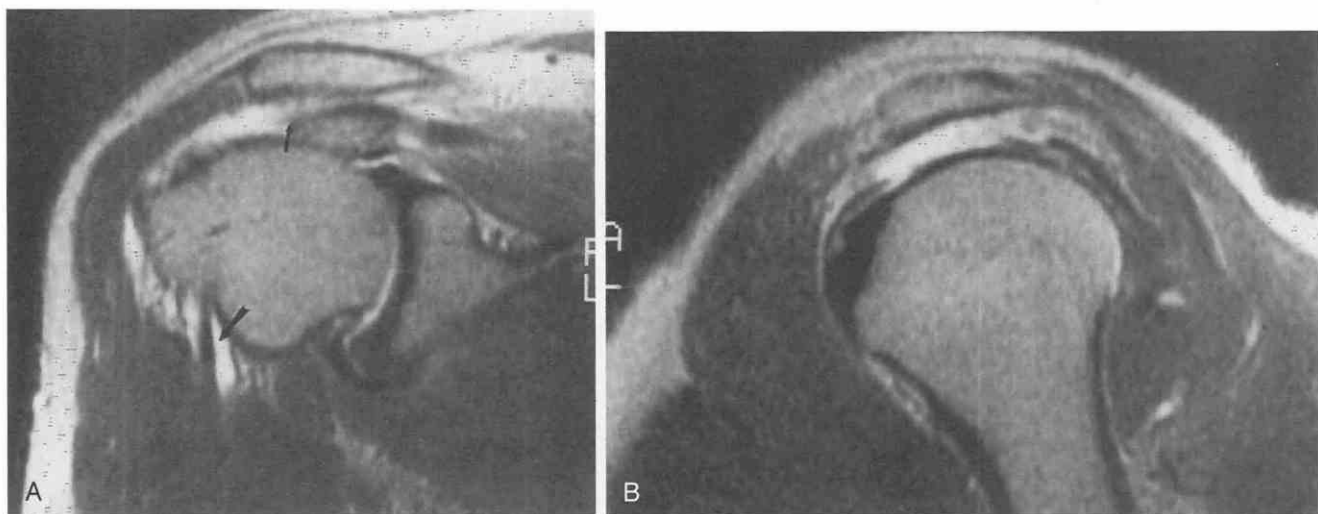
Large cuff tear. *A*, T2-weighted (TR = 2500 msec, TE = 70 msec) coronal oblique image. Bright-signal fluid spills from the glenohumeral joint through a large rent in the rotator cuff into the subacromial-subscapular bursa. Joint fluid also tracks down the sheath of the long head of the biceps brachii muscle (*arrow*). The supraspinatus tendon is retracted (*small arrow*). *B*, T2-weighted (TR = 2500 msec, TE = 70 msec) sagittal oblique image. The large size of this tear may be best appreciated on this sagittal image. At surgery, the tear included all of the supraspinatus, most of the infraspinatus, and the superior part of the subscapularis.
